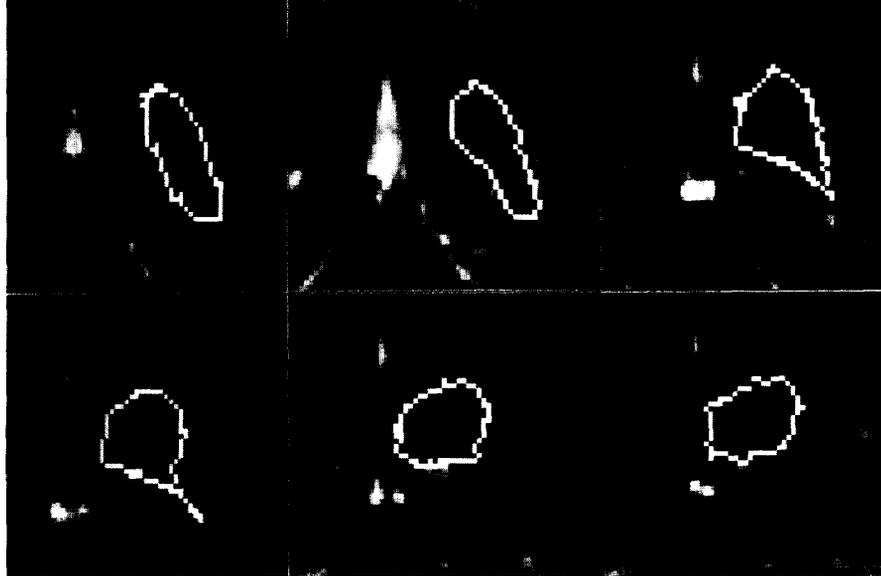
The extracted contours superimposed on the magnetic resonance images of the brain ventricles
